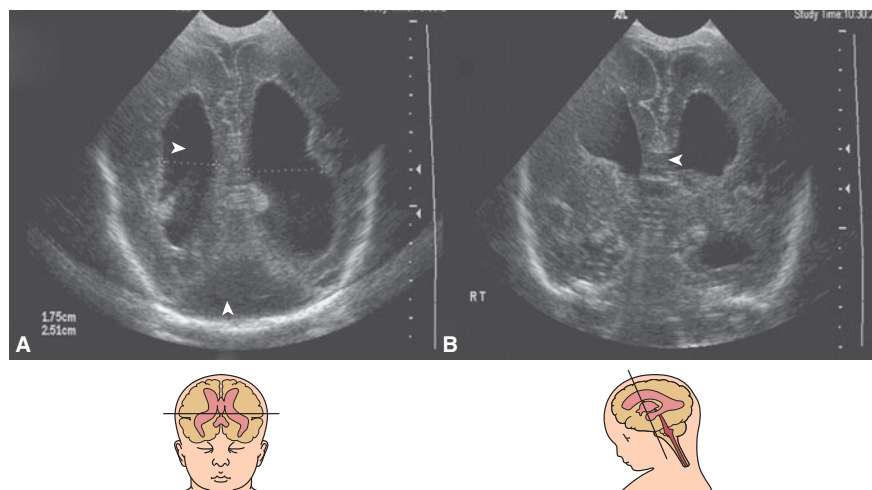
Axial sections on cranial ultrasound (US) in an infant with pyruvate dehydrogenase deficiency on day 1 of life. (A) Ventriculomegaly and posterior fossa cyst (*arrowheads*) can be identified. (B) Callosal dysgenesis (*arrowhead*) and unusual shape of the frontal horns are also identified. Note the abnormal sulcation in both figures.
